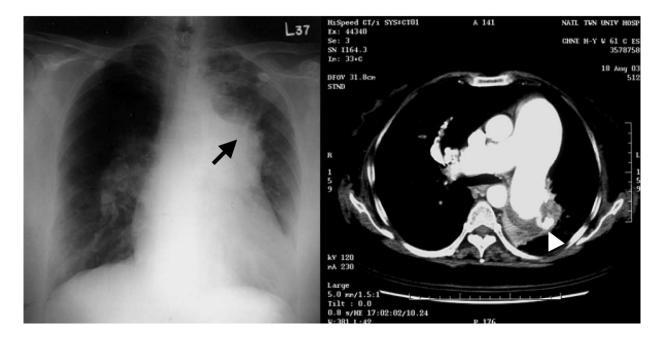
Left, Chest radiograph showing cardiomegaly and a bulging pulmonary conus, with a hazy, ill-defined shadow extending upward from the pulmonary conus (arrow). Right, Chest CT with contrast enhancement revealing an abnormal consolidation around the dilated left pulmonary artery near the hilar area. There was an irregular tract extending from the pulmonary artery into the consolidation mass, suggesting extravasation (arrow head) of the infected pulmonary artery.
